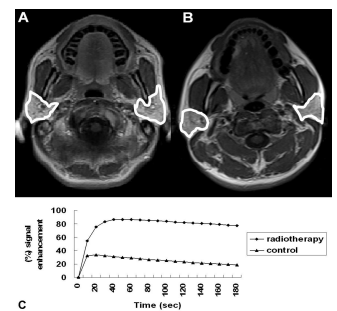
Peak-enhanced T1-weighted images of irradiated (A) and control (B) parotid glands and their corresponding signal enhancement-time curves (C).
